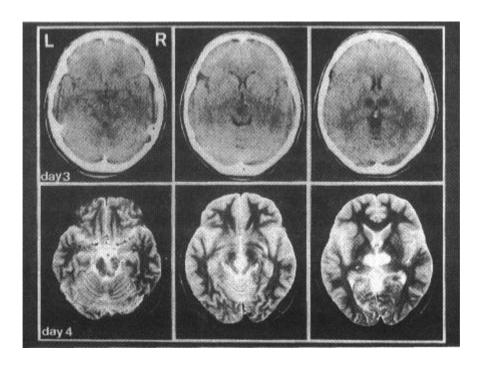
Axial cerebral CT 3 days after and MR showed in T2-weighted images 4 days after the onset.
